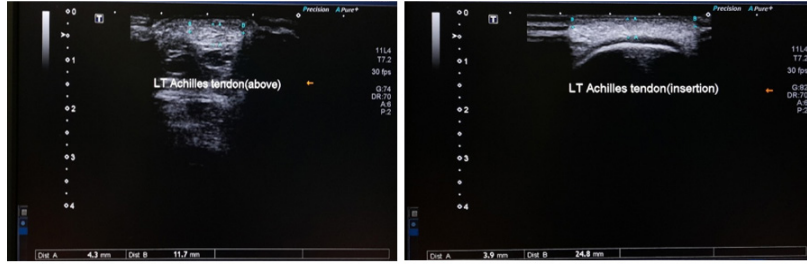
Linear MSK ultrasound of the same patient. The left AT measurements (thickness at the AT insertion into the calcaneus and above insertion: 3.9 mm and 4.3 mm, respectively; the width at the AT insertion into the calcaneus and above insertion: 24.8 mm and 11.7mm, respectively).
